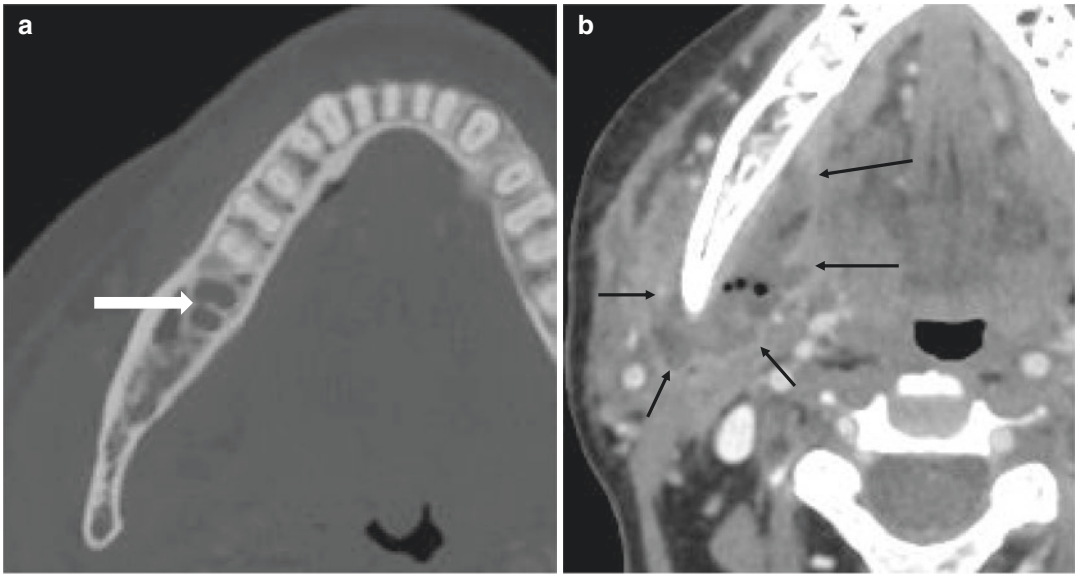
(a) Axial CT bone window showing alveolar lucency corresponding to the socket of a recently extracted lower right seventh molar tooth (thick white arrow). (b) Axial CT soft tissue window showing a rim enhancing masticator space abscess containing locules of gas surrounding the posterior body of the right mandible (thick black arrows)
